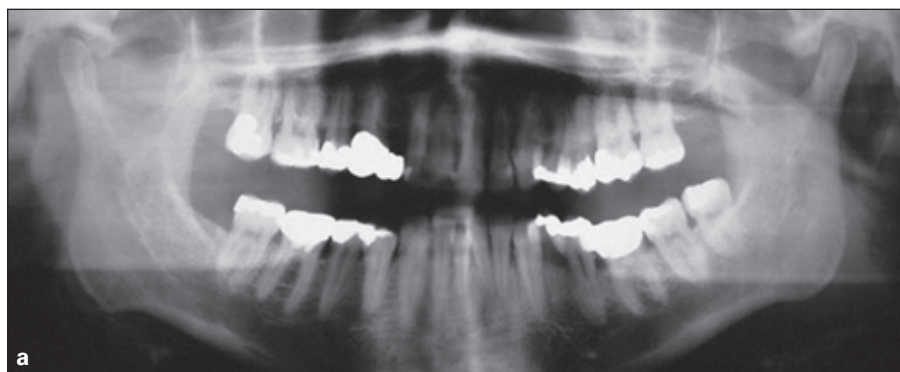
(a) Pretreatment and (b) post-treatment panoramic radiographs and (c) 1-year posttreatment orthopantomographic sectional images of both joints.
